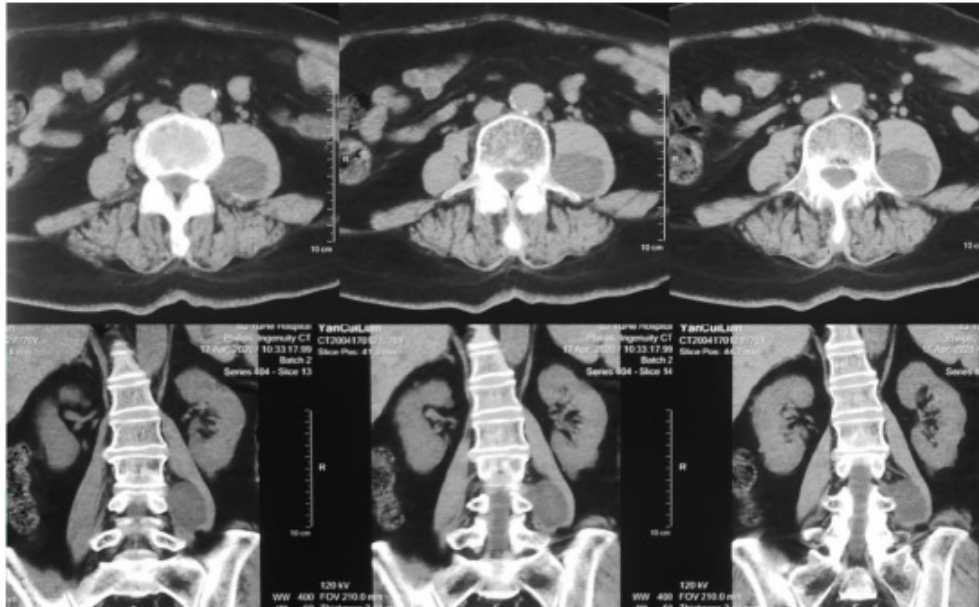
CT examination of lumbar spine shows a space occupying lesion in the psoas major muscle on the left side at the lumbar 3-4 level.
